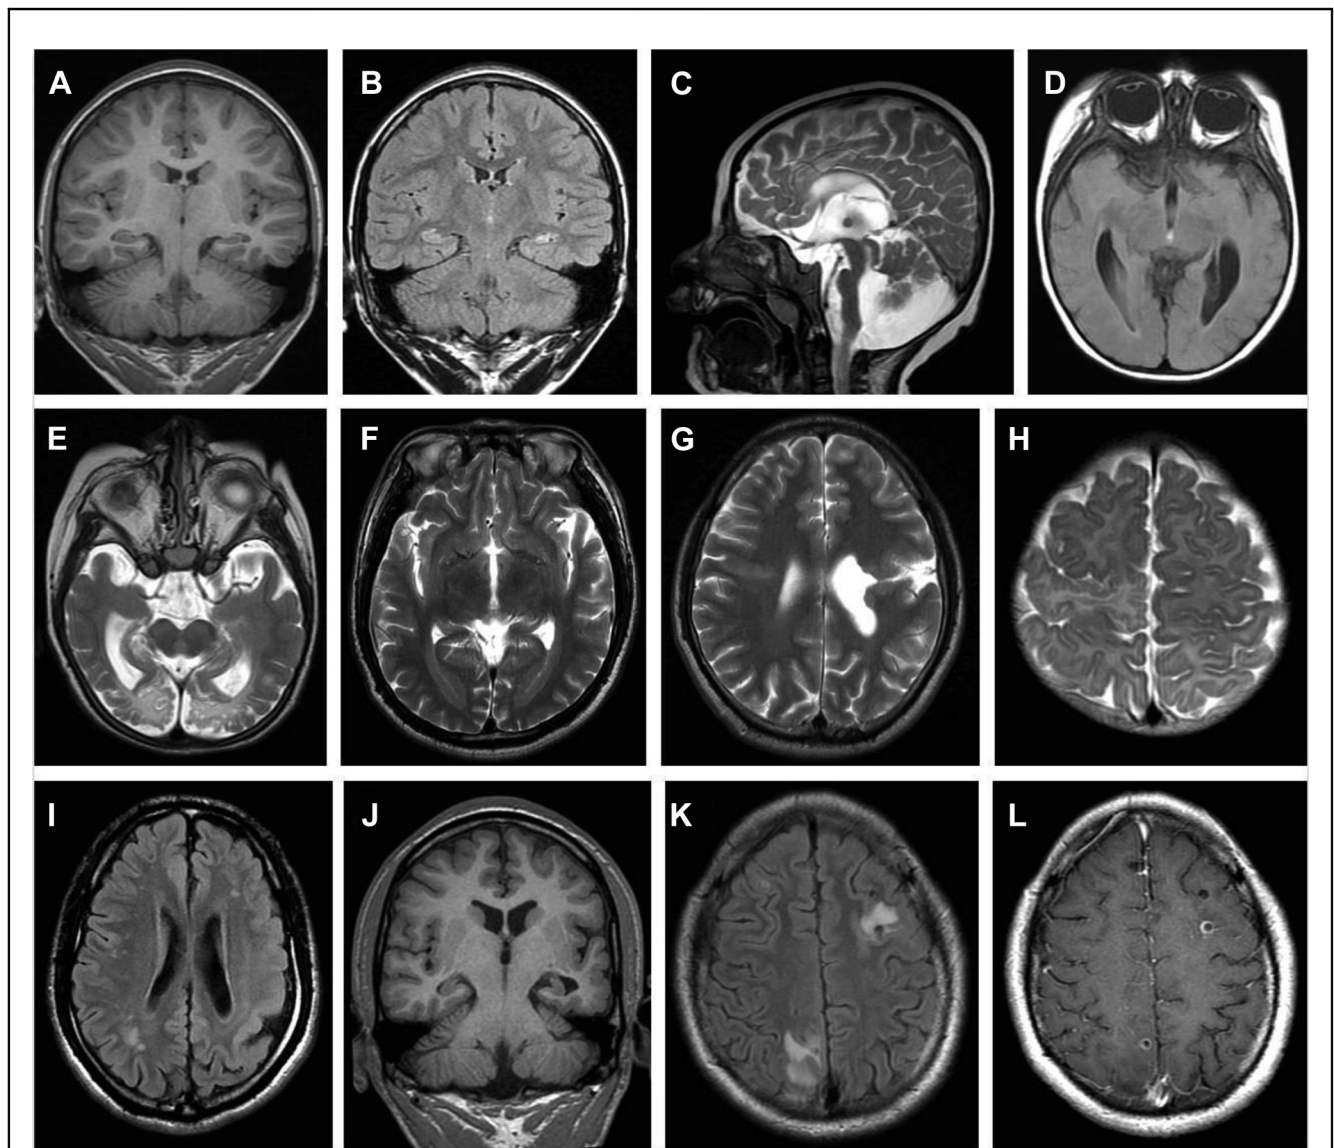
MRI findings of epilepsy-related pathologies among people with epilepsy in Bhutan. (A, B) Coronal T1 and T2-FLAIR images of a girl with bilateral hippocampal sclerosis. (C, D) Sagittal T2 and axial T1 images of a boy with multiple midline malformations including corpus callosum, brainstem, and cerebellar vermis dysgenesis and hypotelorism. (E) Axial T2 image of a girl with bioccipital cortical dysplasia and polymicrogyria and bitemporal lissencephaly. (F) Axial T2 image of a woman with symmetric posterior periventricular gray matter band heterotopia. (G) Axial T2 image of a man with a left frontal open-lip schizencephalic cleft and less severe right frontal cortical dysplasia. (H) Axial T2 image of a girl with right perirolandic cortical dysplasia and polymicrogyria. (I, J) Axial and coronal T2-FLAIR image of a man with left parietal pachygyria and lissencephaly associated with diffuse hypoplasia of the left hemisphere. (K, L) Axial T2-FLAIR and T1-postcontrast images of a 24 year old man with multiple intracerebral viable and degenerating neurocysticercosis lesions. Several lesions show ring enhancement with gadolinium and are surrounded by vasogenic edema. A scolex is visible in the nonenhancing left frontal lesion.
